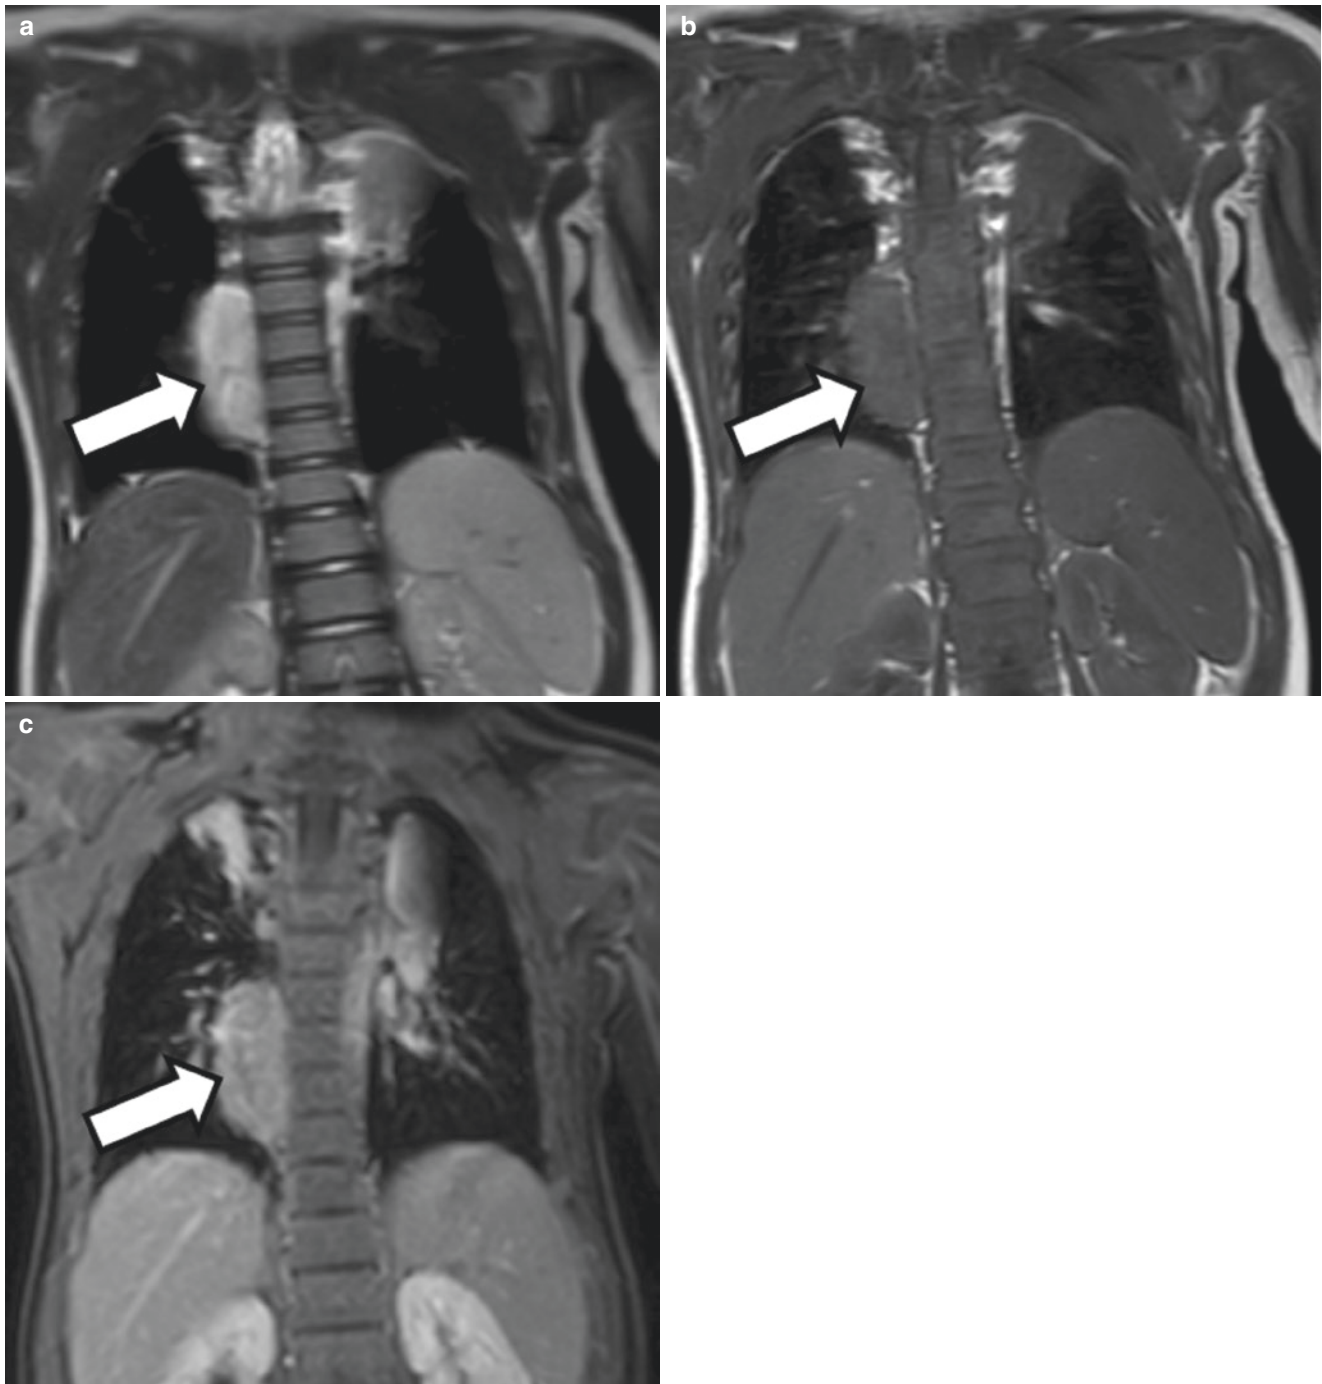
A 19-month-old girl with thoracic neuroblastoma. (a) Coronal T2-weighted MR image shows a right paraspinal mass (arrow), which is hyperintense to the adjacent skeletal muscle. (b) Coronal T1-weighted MR image shows a right paraspinal mass (arrow), which
